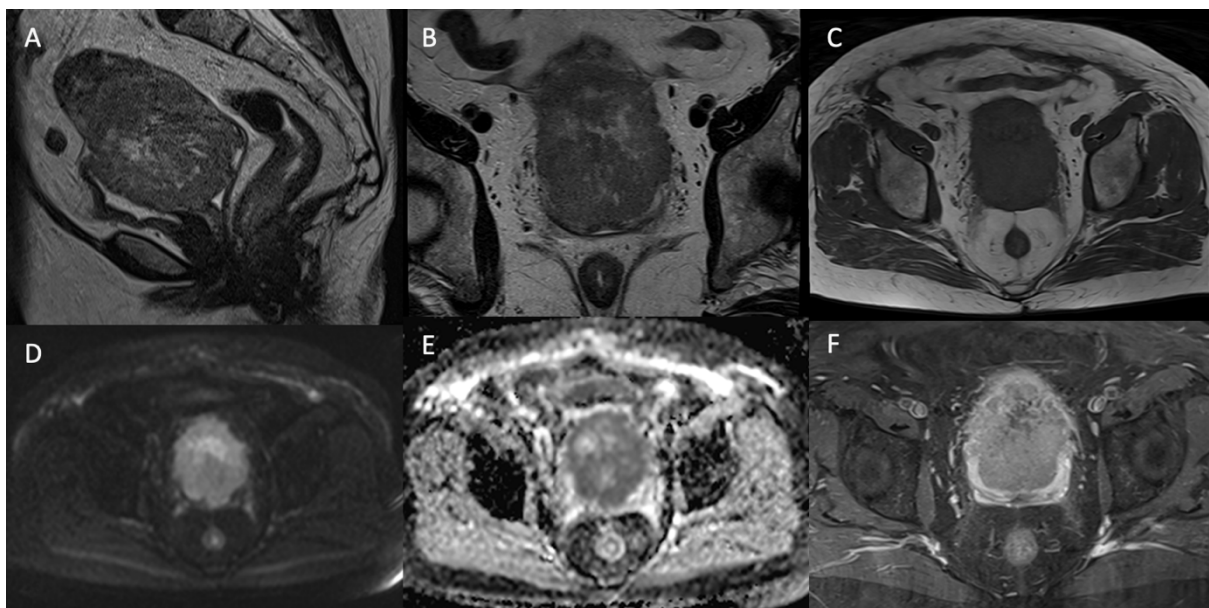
Sixty-seven-year-old female patient with no clinical manifestations, with a lesion discovered in a routine checkup. A B Sagittal and axial T2WI showed a heterogenous hyperintense lesion; C Axial T1WI revealed isointense lesion; D E High signal on DWI, higher than the endometrium and low signal on the ADC map. ADC mean value was $(0.806 \times 10^{-3} \text{ mm}^2/\text{s})$. F T1 FS postcontrast axial image with heterogeneous low enhancement. Pathology revealed leiomyosarcoma.
